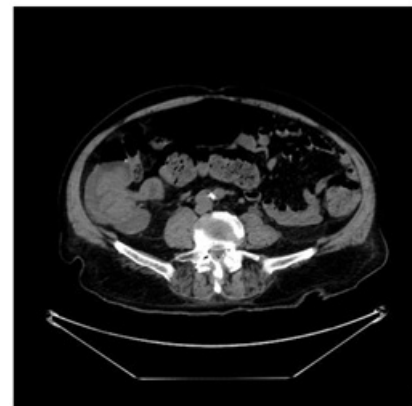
Sagittal CT image showing the presence of a large mass in the cecum that attracts the long sigmoid colon, with suspected presence of a second lesion of the sigma or diffusion by continuity of the neoplasm of the cecum.
